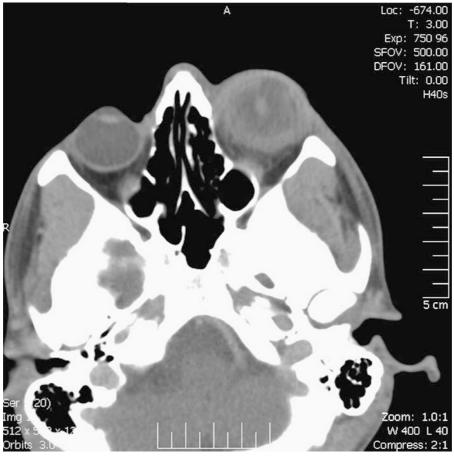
Axial section of MRI head scan showing proptosis, enlargement of the globe, posterior dislocation of the lens, thickening of the peri-orbital soft tissue, and posterior wall of the globe in the left eye.
